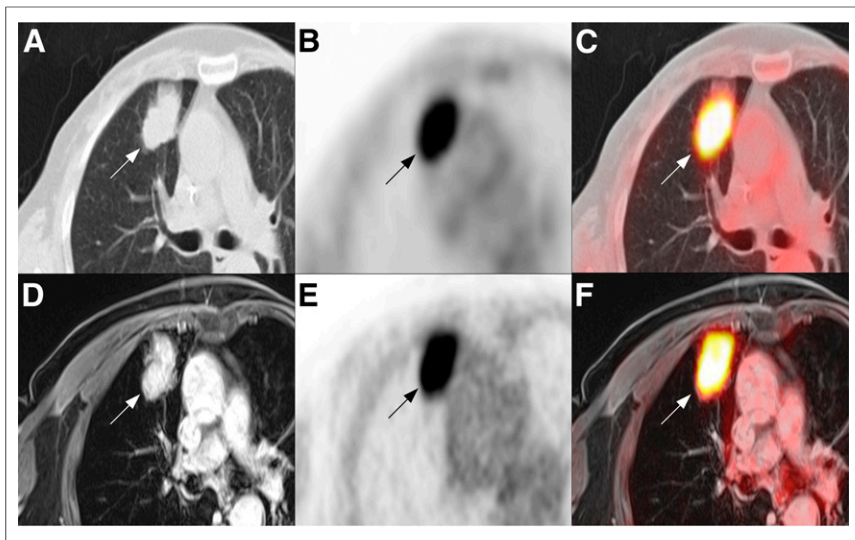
In 65-year-old woman with lung cancer, 38-mm tumor (arrows) is seen in right upper lobe of lung on CT component (A) of PET/CT (C) and on MRI component (D) of PET/MRI (F). SUV_{max} of strong ^{18}F -FDG uptake on PET component is 17.3 for PET/CT (B) and 19.4 for PET/MRI (E).
